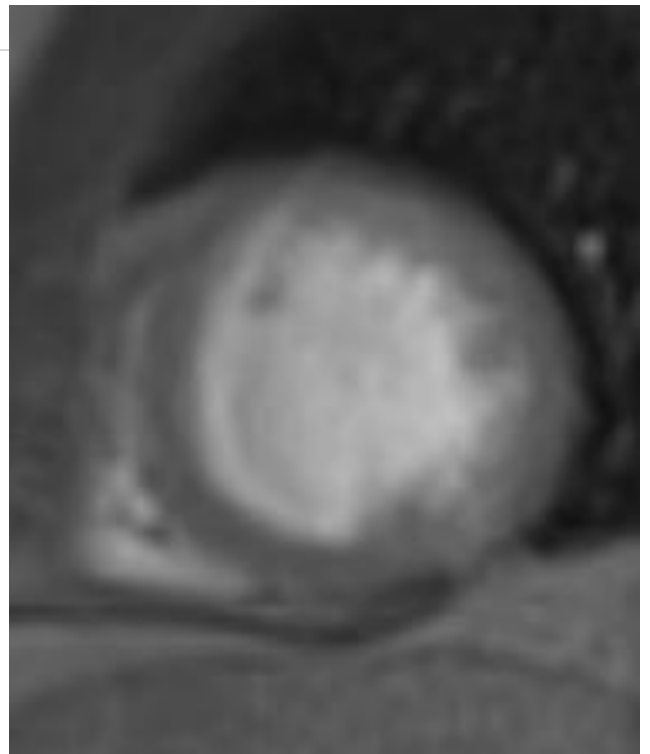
Territorial analysis of MRI and CAG
